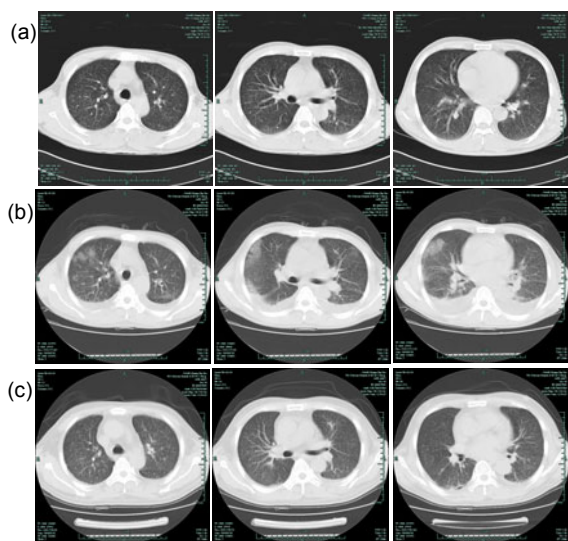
Chest CT scans of Case 1
